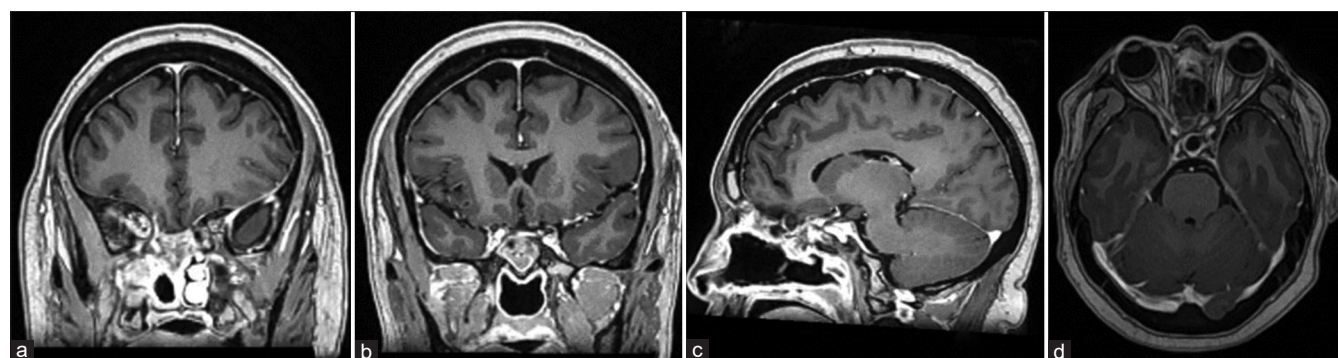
Postoperative magnetic resonance imaging. Coronal T1WI C+ (a and b), sagittal T1WI C+ (c), and axial (d), T1WI C+. No residual lesion or evidence of skull base involvement is observed. The straight gyri of both frontal lobes present areas of encephalomalacia, without evidence of abnormal enhancements.
